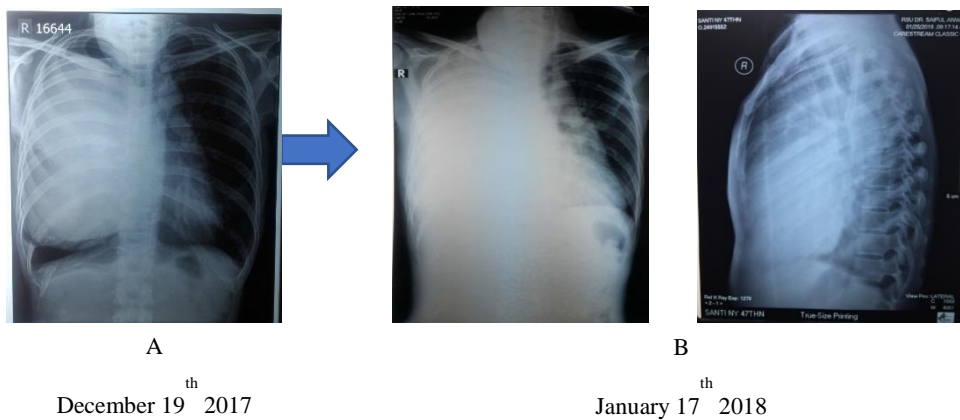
Comparison of Chest x-ray before surgery, getting worse.
